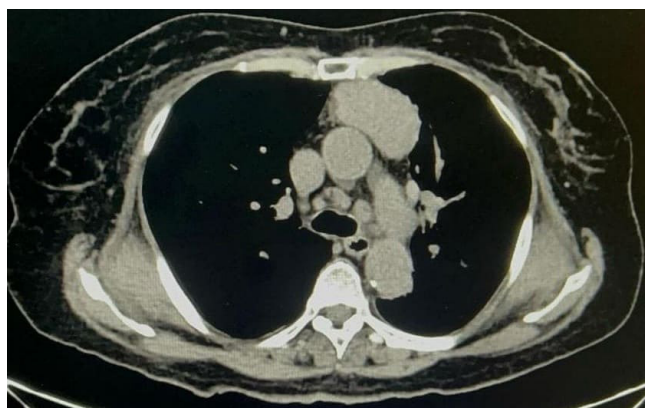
Axial computed tomography scan showing a mediastinal mass above the pulmonary artery.
